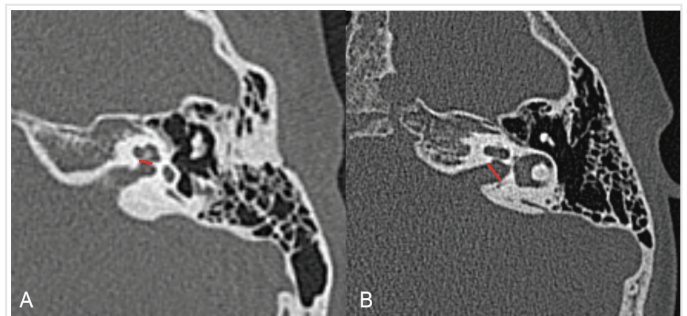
(A) CNCW measurement at the mid-modiolar plan on axial CT images. (B) IACW measurement at the mid-point in axial CT sections
